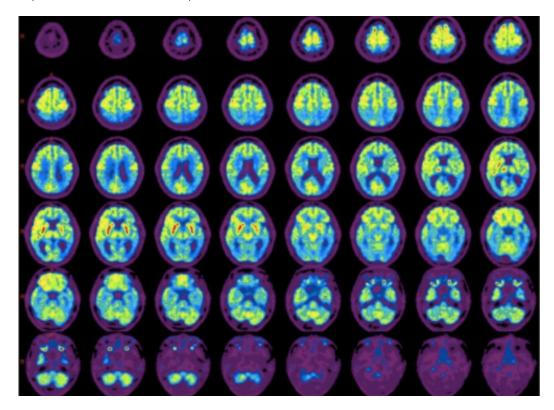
Fluoro-deoxyglucose PET images. Generalized decreased FDG uptake in the biparietal, bitemporal and bioccipital lobes with mild decreased uptake in the bifrontal lobes.
